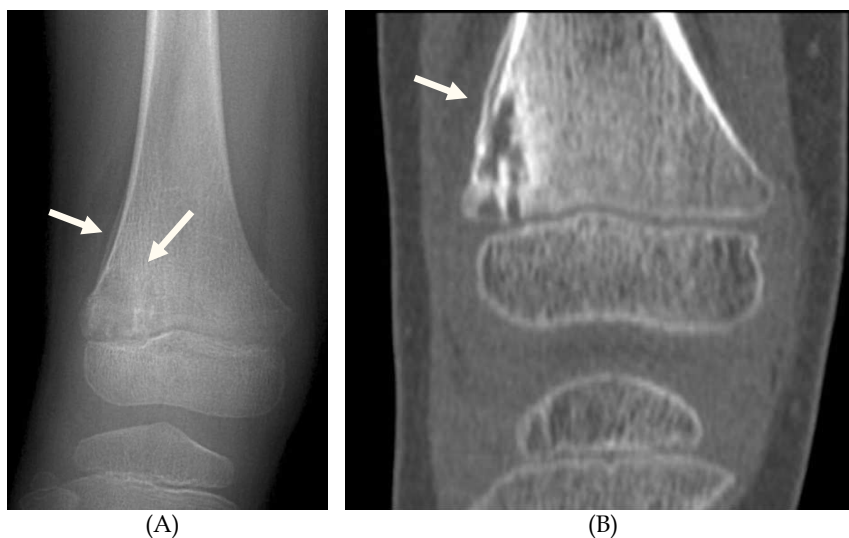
Images of a 4.5-year old girl at CRMO diagnosis. (A). Anteroposterior radiograph of the right distal femur reveals an ill-demarcated focal pyramidal lesion in the lateral aspect of the distal right femur associated with single-layered periosteal reaction and soft-tissue edema. (B).A coronal reformat from CT images of the distal femur better delineates the bony changes.
